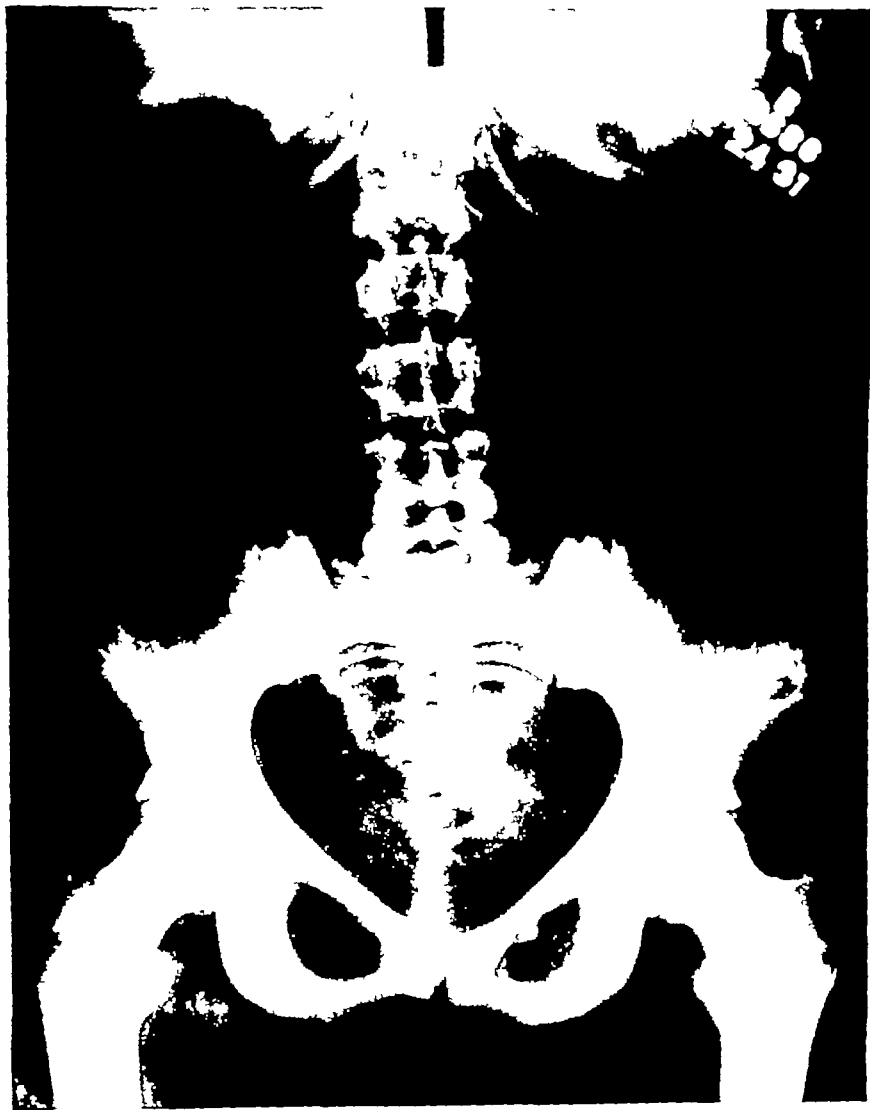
X-RAY OF PELVIS IN MRS. M. D., PATIENT THREE
